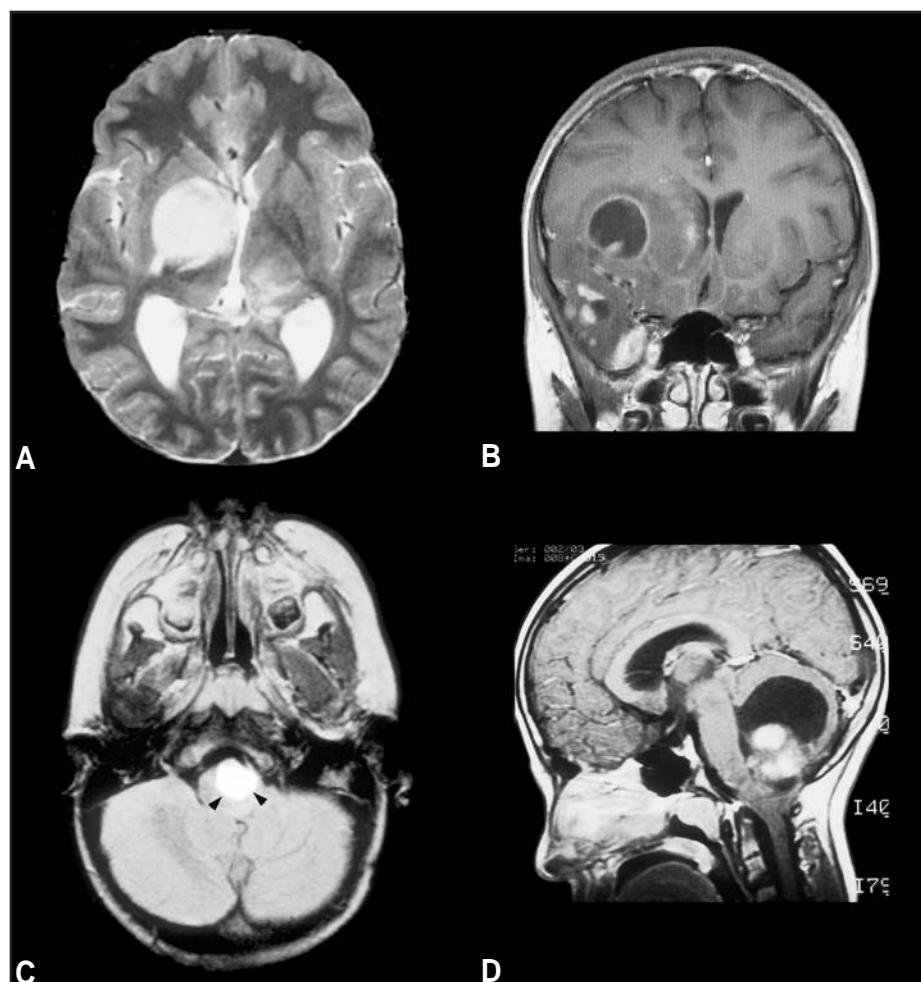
Neuroimaging of pilocytic astrocytoma. A Solid, well-circumscribed hyperintense hemispheric lesion in a T2-weighted image. B Pilocytic astrocytoma of the frontal lobe presenting on T1 MRI as a hyperintense mural nodule with a large cyst. C Discrete pilocytic astrocytoma in the medulla (T1 MRI). D Cystic cerebellar lesion with a contrast-enhancing mural nodule.
